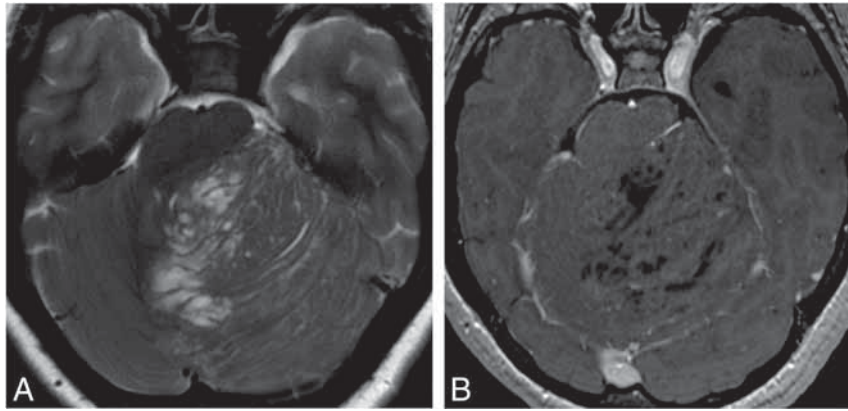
Dysplastic gangliocytoma of the cerebellum in a 19-year-old man with Cowden syndrome. Grossly thickened cerebellar folia with a tiger-striped pattern and rare patchy enhancement in the superior vermis and left cerebellar hemisphere. Axial T2-weighted image (A). Axial T1-weighted fat-saturated contrast-enhanced image (B).
